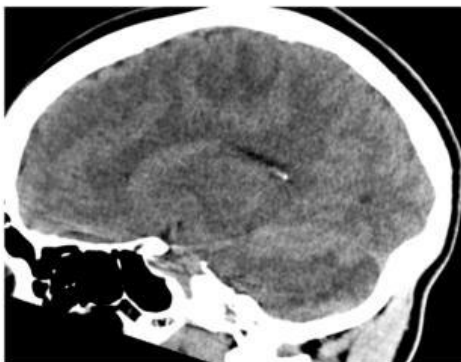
CT Head demonstrates accentuated grey-white differentiation in the cerebellum reflecting edema in the cerebellar white matter.
